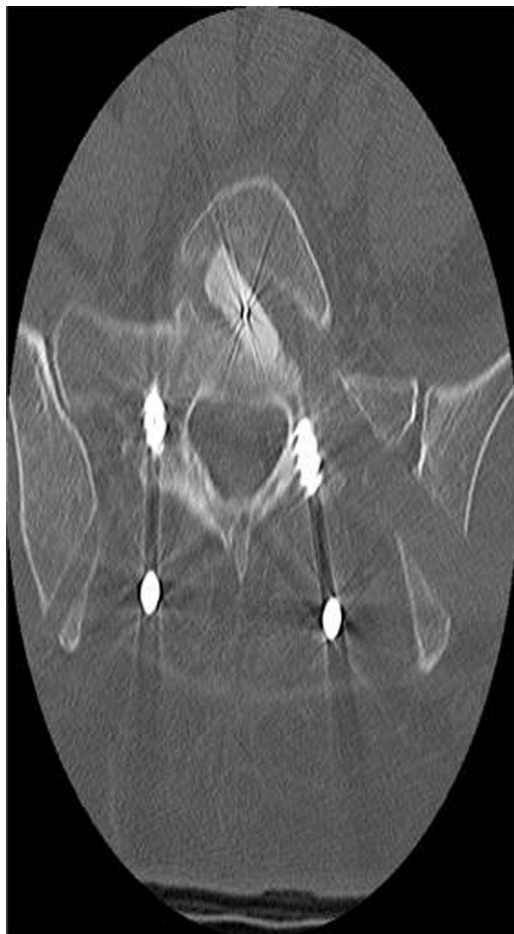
Postoperative axial CT image of interbody device position.
